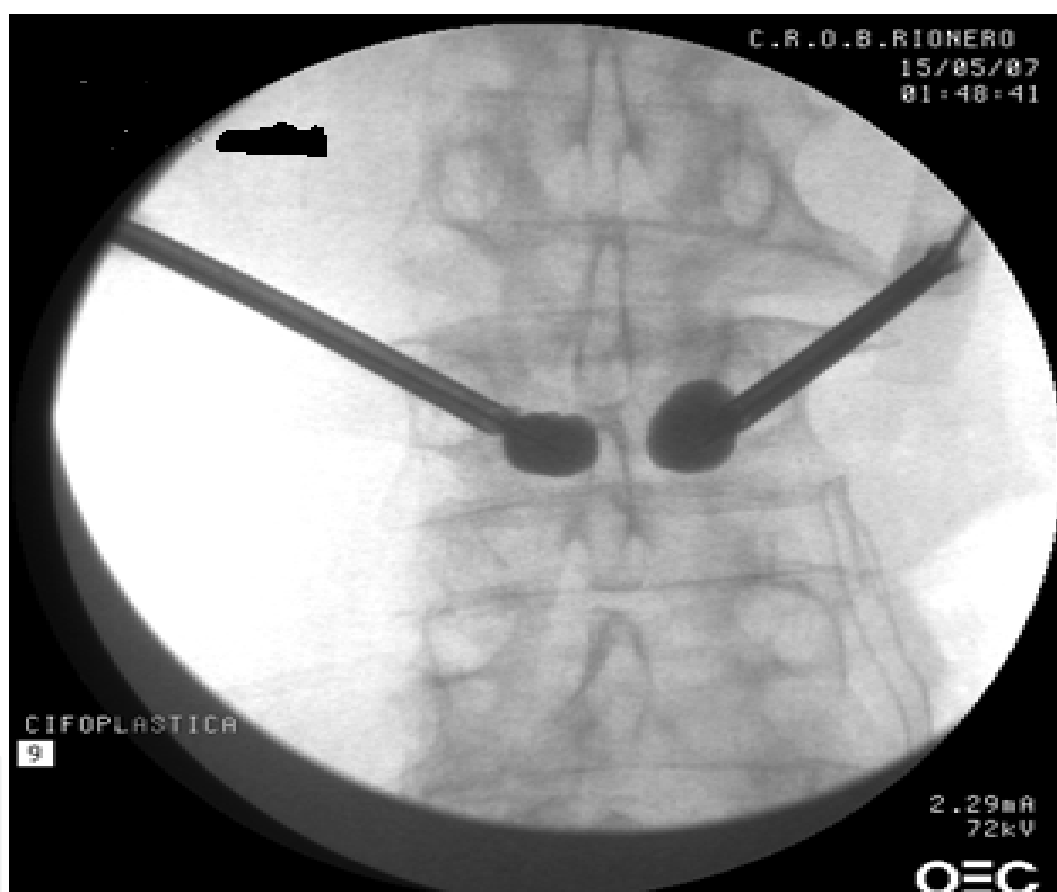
AP X-ray image of kyphoplasty
